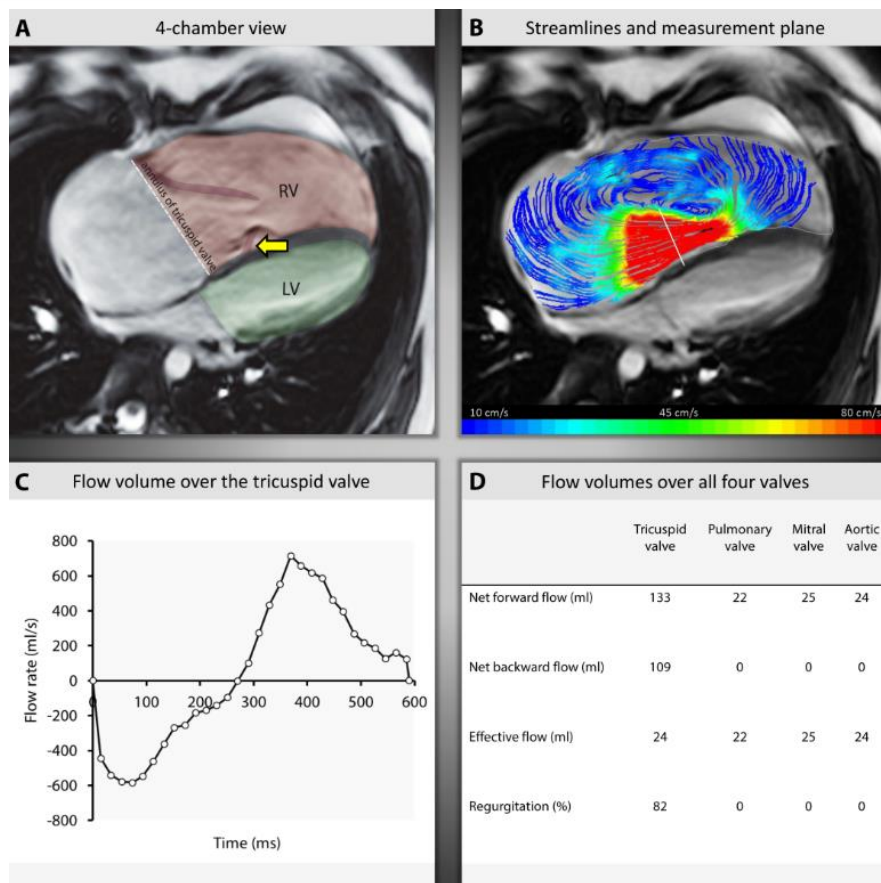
Direct assessment of Tricuspid Regurgitation by 4D flow MRI in a Patient with Ebstein's Anomaly
